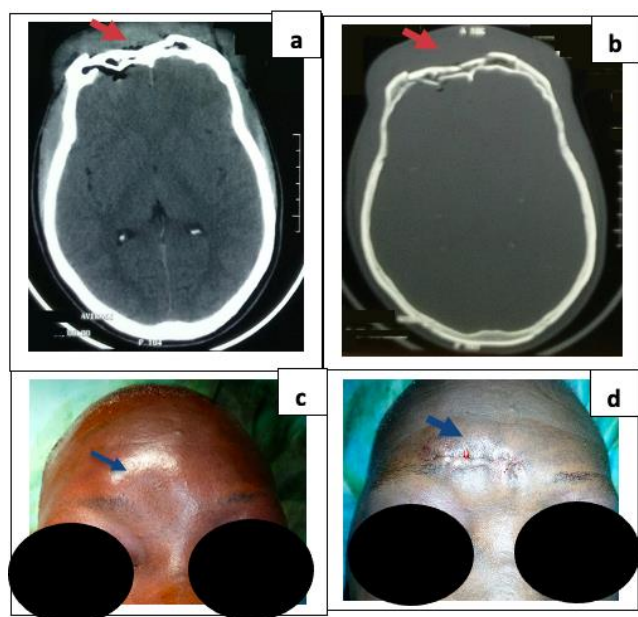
CTscan and clinical images of a right frontal sinus depressive fracture operated through an incision in a frontal skin fold centered on bone depression. Preoperative CT scan images in axial section of parenchymal (a) and bone window (b) showing a compressive right frontal sinus depressive fracture with slight pneumocephaly opposite. Preoperative clinical image showing right mediolateral frontal bone depression (c); immediate postoperative post after depressive fracture removal, cranialization and obliteration of frontal sinus showing barely visible incision made in a frontal skin fold.
